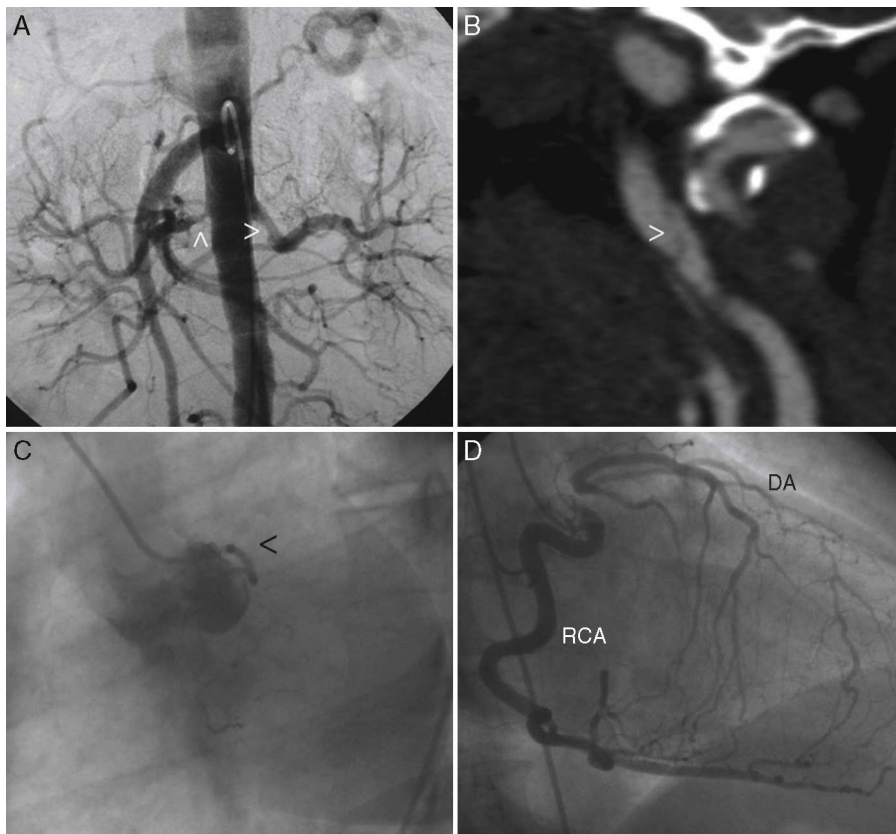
(A) Abdominal aortography evidencing proximal stenosis at both renal arteries level (arrowhead). (B) Angiography by computed tomography where it is possible to observe left carotid artery dissection (arrowhead). (C) Left coronary catheterization (left anterior oblique) where only a poor-developed circumflex artery can be seen (arrowhead). (D) Right coronary catheterization (left anterior oblique) that evidences a dominant right coronary artery (RCA) that fills for collateral circulation of descending artery (DA), which is occluded at proximal level.
